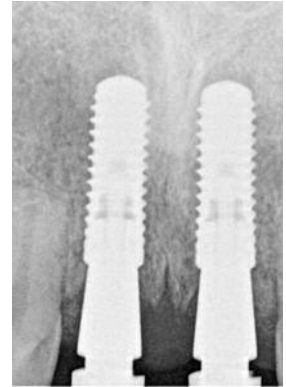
Verification of impression copings on radiograph.
